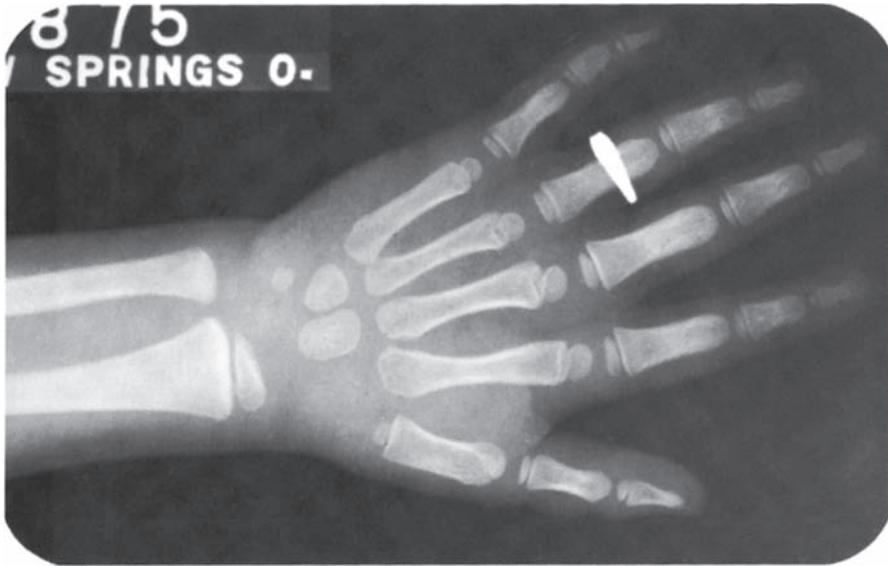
Hand-wrist X-ray of a 3-year-old.
